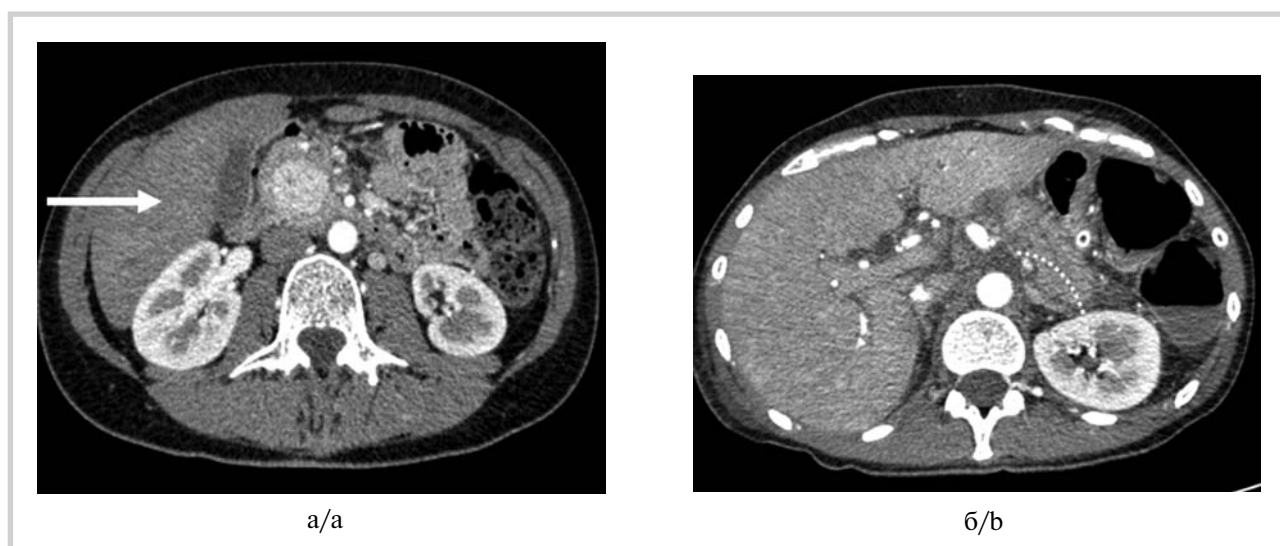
CT-scan, arterial phase, axial plane. A — control follow-up in 6 months after distal pancreatectomy: NET (Grade 2) of the pancreatic head 26×26 mm. B — residual pancreatic parenchyma after partial pancreateoduodenectomy and distal pancreatectomy.
